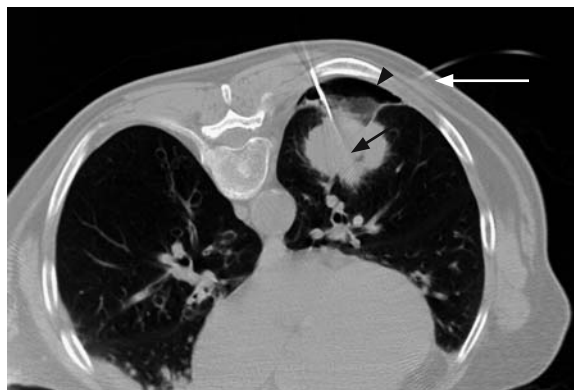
CT-guided catheter drainage of an iatrogenic pneumothorax during a radiofrequency ablation procedure. a – Pneumothorax (arrowheads), with RF needle (black arrow) and percutaneous catheter in situ (white arrow). b – Treated pneumothorax (SHANKAR et al. 2003)
